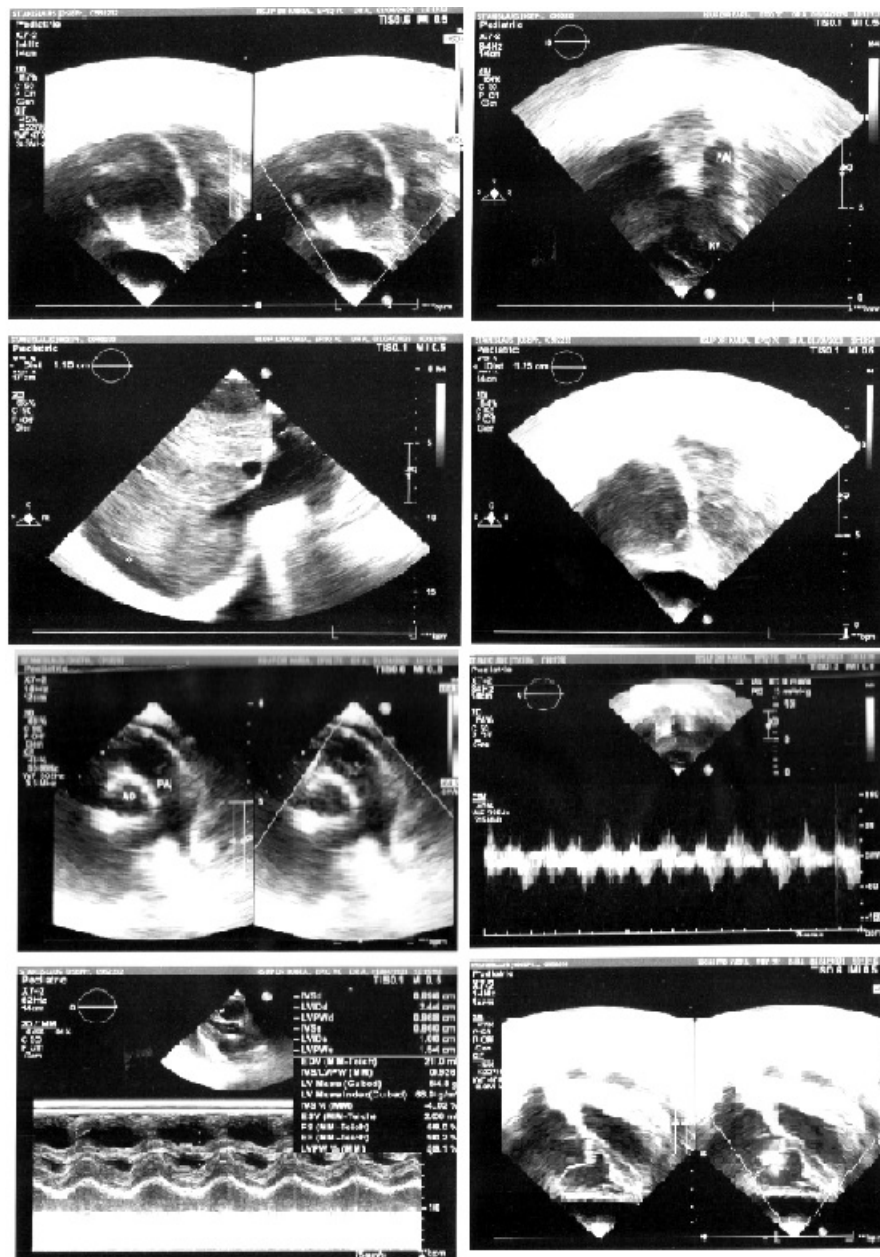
Echocardiography (before pericardial window surgery) : massive pericardial effusion and restrictive cardiomyopathy
